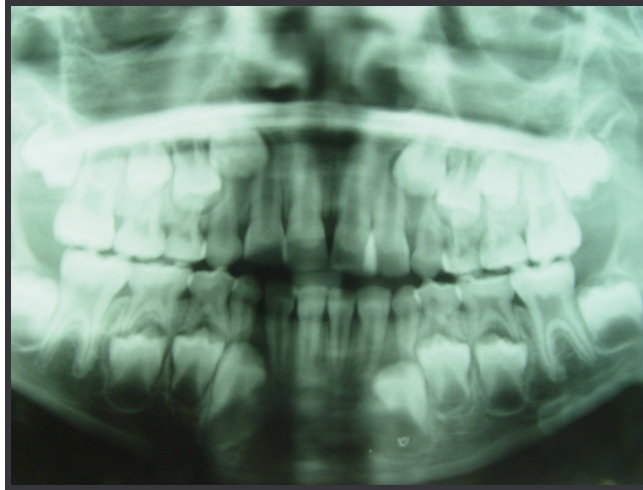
Panorex radiograph illuminated on the viewing light box
